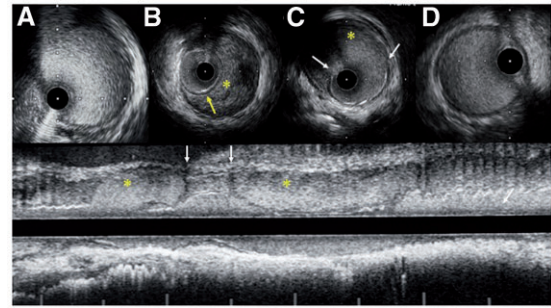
Longitudinal intravascular ultrasonography images showing (A) absence of dissection at the origin of the left internal thoracic artery and (B) intramural haematoma (*), confirmed by the white-black-white appearance of the intimal-medial membrane (yellow arrow). (C) The intramural haematoma (*), extending proximally and distally from the site of dissection (white arrows). (D) Intact middle portion of the left internal thoracic artery.
